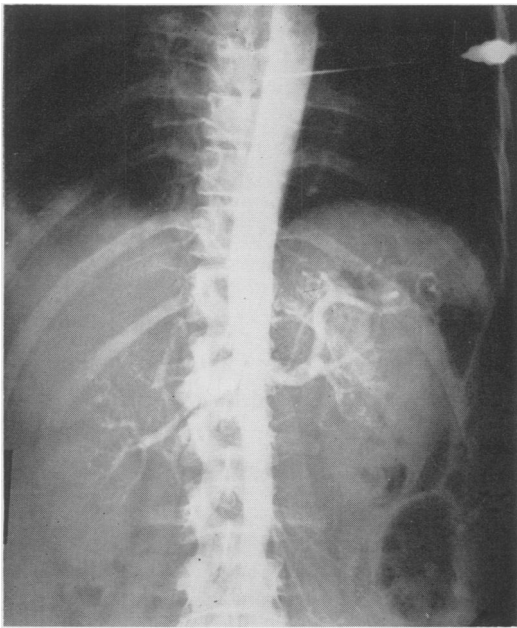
Transthoracic aortogram demonstrating sacular accumulation of dye in region of celiac axis, that is, just above right renal artery.
